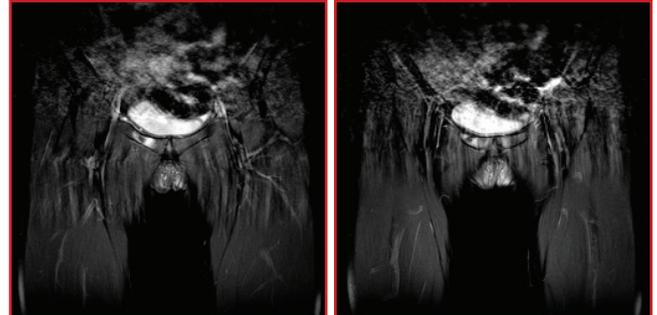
MRI showing new right superior pubic ramus and left inferior pubic ramus fractures. Incompletely healed (delayed healing given the intervening time) right inferior pubic ramus fracture.
